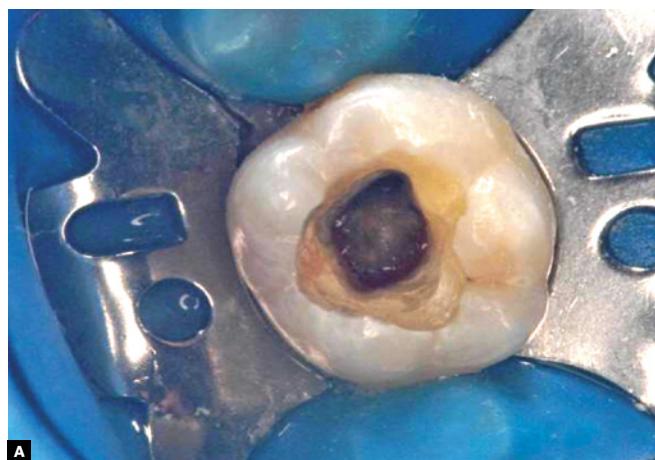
A) Removal of pulp chamber roof and exposure of root canal openings. B) Periapical radiograph evincing the presence of communication between pulp chamber and furcation area. C) Image presenting accessory canal in furcation area near mesial canal openings.
